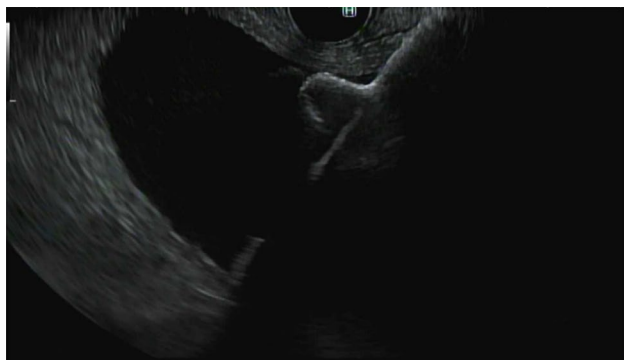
Endoscopic ultrasound-guided deployment of the distal phalange of the lumen-apposing stent into the gallbladder lumen
